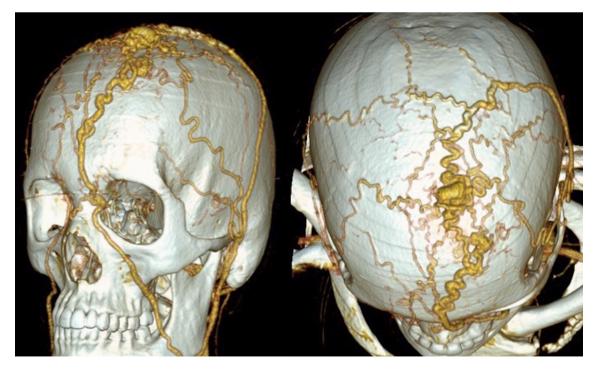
CT – angiography of the vessels of the head, 3D – reconstruction: Arteriovenous malformation of the frontoparietal region with afferents from the right and left superficial temporal artery, facial artery.
